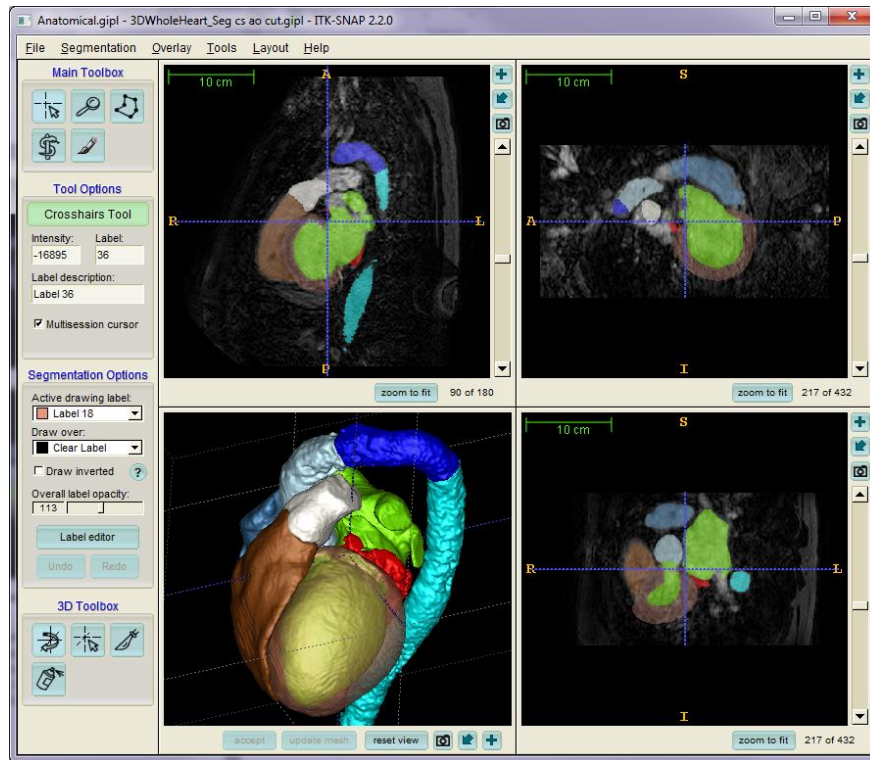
Snapshot of the ITK-SNAP segmentation tool showing three orthogonal views (*top left*: sagittal, *top right*: coronal, *bottom right*: axial) of a 3D MR image and a surface rendering of the segmented heart (*bottom left*). Regions segmented from this image include the ascending aorta (*light blue*), aortic arch (*blue*), descending aorta (*cyan*), coronary sinus (*red*), pulmonary artery (*white*), left atrium (*green*), left ventricle myocardium (*bronze, translucent*) and blood pool (*green, embedded*), right atrium (*azure*), and right ventricle blood pool (*brown*).
